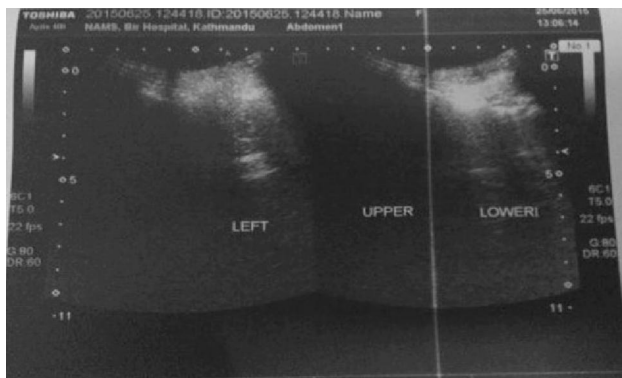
Sonography of left maxillary sinus showing visualization of posterior wall in lower part, which is located more than 3.5 cm from skin surface. There is air shadow and nonvisualization of posterior wall echo complex in upper part. Findings are consistent with air fluid level.
